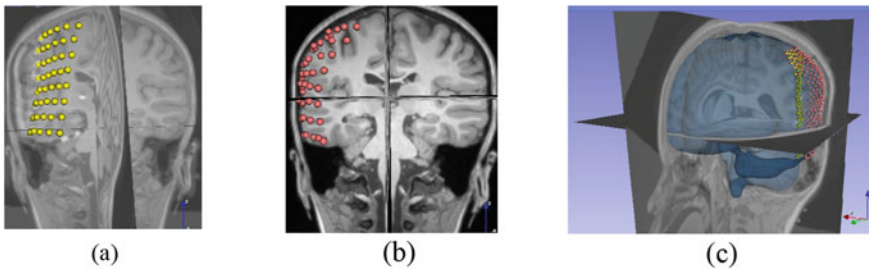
External Load a Visualization of 3D intracranial electrodes (yellow) on a preoperative MRI rigidly aligned with CT image, b Visualization of projected electrodes (red) on MRI, c Visualization of brain nodes pre-transformed (red) and transformed (yellow) along with 3D brain model (blue with reduced opacity) on preoperative MRI rigidly aligned with CT image. Visualization performed with 3D Slicer www.slicer.org [5]
